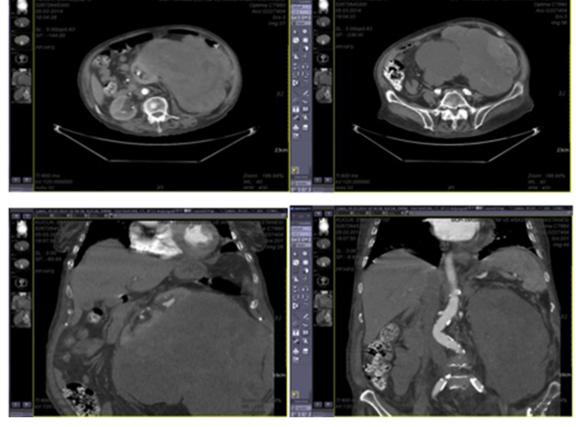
CT scan of the left kidney mass.
